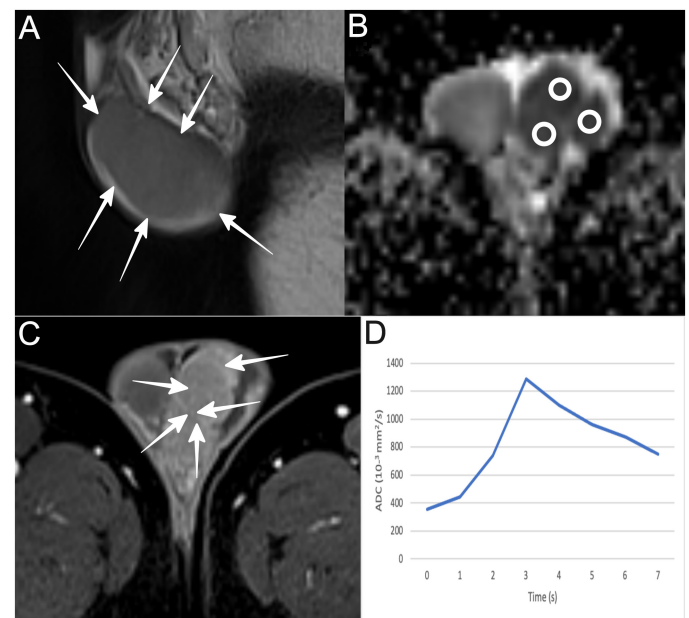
Left testicular seminoma in a 55-year-old man. (A) Sagittal T2-weighted image shows large hypointense left testicular mass (arrows), replacing the ipsilateral testis. (B) Axial ADC map ($b = 800 \text{ s/mm}^2$) shows tumor's restricted diffusion. The mean ADC values of tumor (circular ROIs) were $0.53 \times 10^{-3} \text{ mm}^2/\text{s}$. (C) Axial DCE image at early phase (180 seconds) shows heterogeneous tumor enhancement. Septal enhancement (arrows) more than the remaining tumoral tissue. (D) TSI curve is typical of malignancy (type III).
